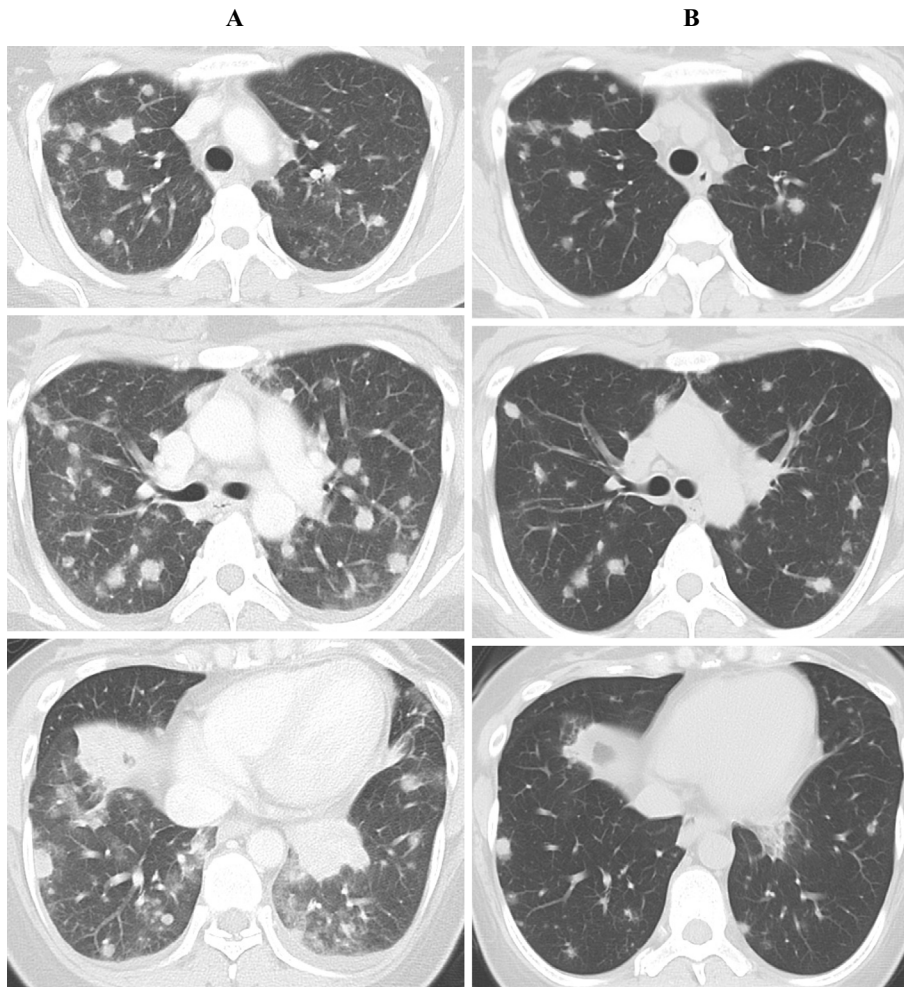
(A) A CT scan on admission. Bilateral multiple nodular shadows are seen in both lung fields. (B) One month after admission, the multiple nodular shadows were found to have decreased in size.
